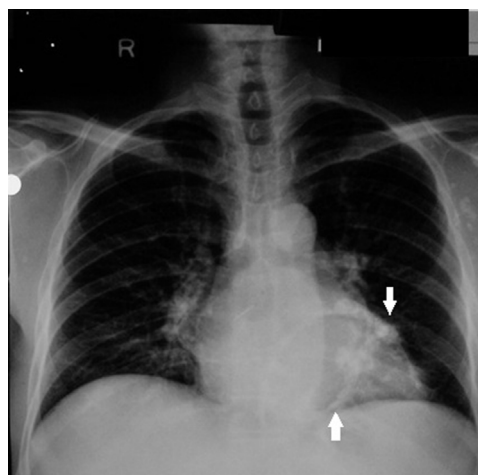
(A) Chest radiograph of a patient showing pericardial calcification primarily in the atrio-ventricular groove.
